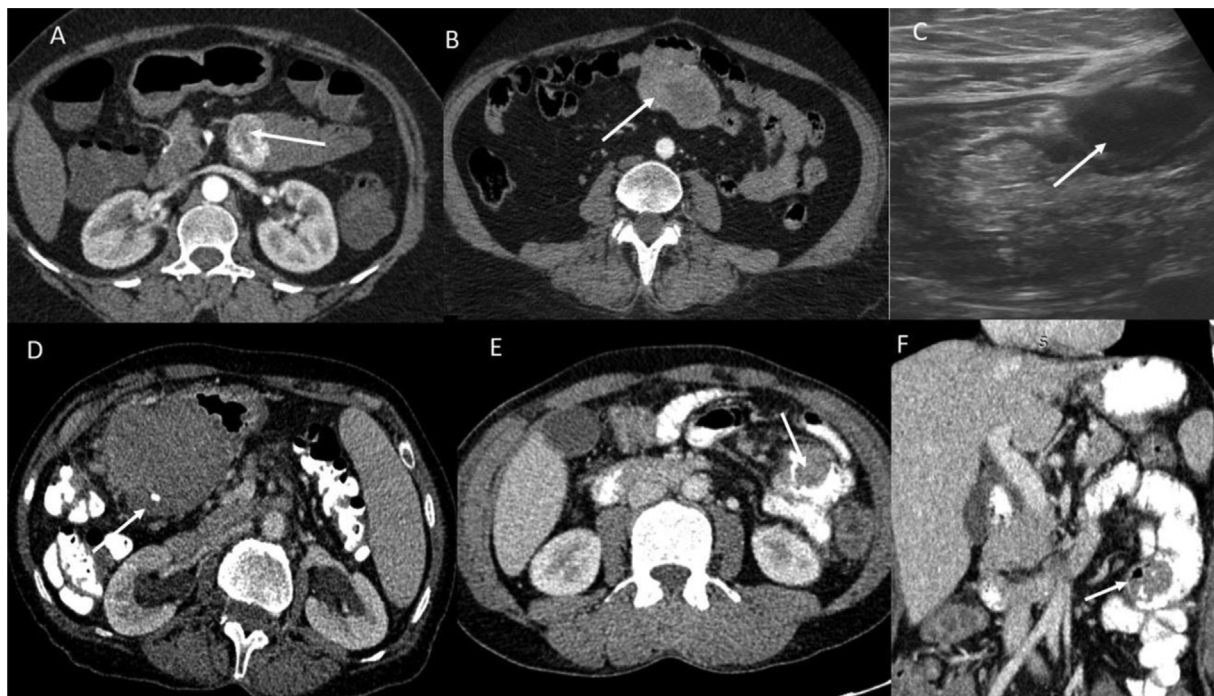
Gastrointestinal stromal tumors: (A) Hypervascular intraluminal mass (arrow) in the D-J flexure/proximal jejunum; (B, C): necrotic tumor involving distal jejunum on computed tomography (CT; arrow in B) and ultrasound (arrow in C); (D) Axial contrast-enhanced CT abdomen showing hypoenhancing exophytic mass lesion arising from stomach with multiple foci of calcification; (E and F) Axial and coronal images showing endophytic jejunal gastrointestinal stromal tumor.
